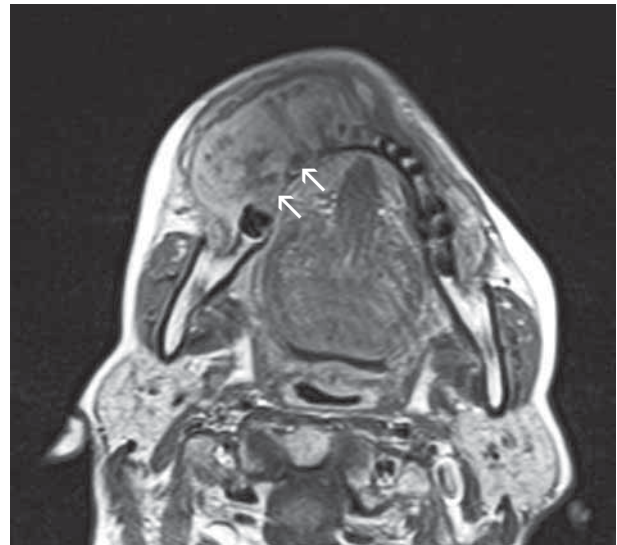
Axial contrast-enhanced T1-weighted image shows osteosarcoma of the mandible. Inhomogeneous well contrast-enhanced tumor mass with osteosclerosis, interrupted cortical bone and decrease in the signal of the bone marrow, which appears grey because of its involvement by the tumor (white arrows).
